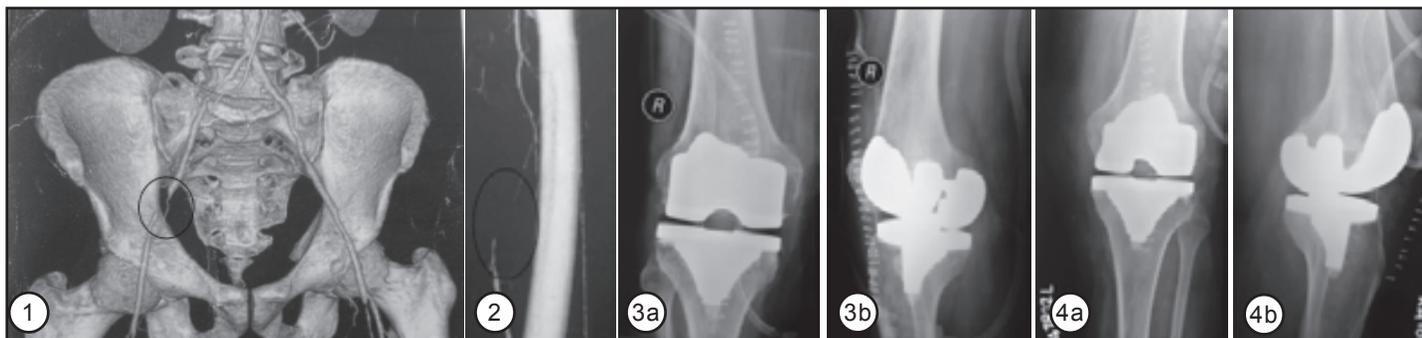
CT Angiogram showing a block in the right external iliac artery with collateral flow; Figure 2: CT Angiogram showing a block in the left superficial femoral artery; Figure 3a and 3b: Post operative Xrays of the right Knee; Figure 4a and 4b: Post operative Xrays of the left Knee
